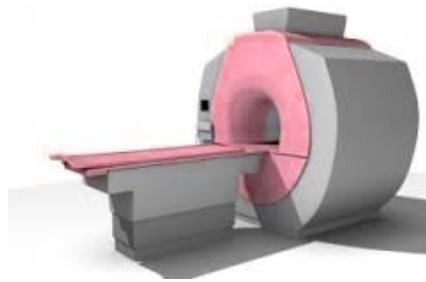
Closed MRI scanner
